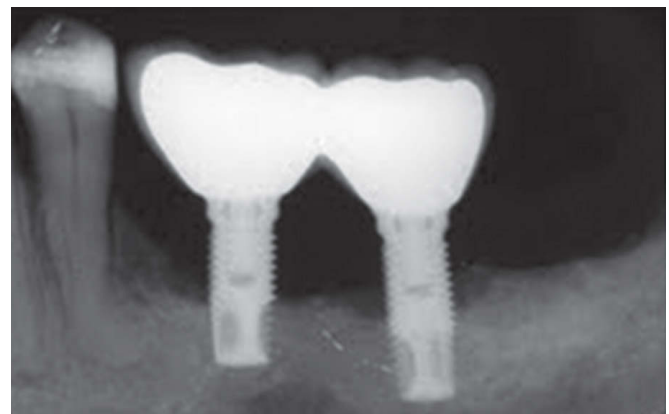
Radiographic image of Figure 2, showing excessive bone loss to the mid third of implants.
